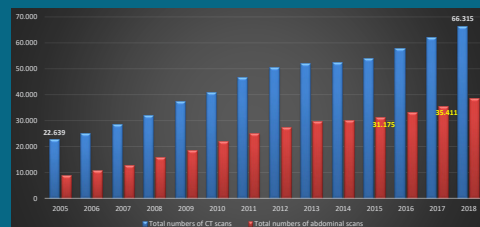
Increase in annual numbers of CT scans performed in the North Denmark Region from 2005 to 2018, compared to the numbers of abdominal CT scans in the same period.
